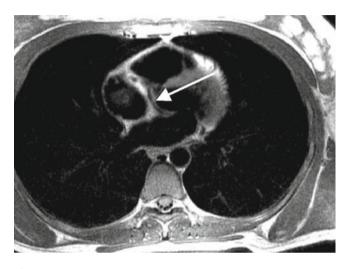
This 45-year-old patient presented with chest pain, underwent X-ray coronary angiography, and was found to have an anomalous left circumflex arising off the right coronary sinus. Regarding the question as to trajectory, the catheterization results were equivocal, prompting a cardiac MRI. This double-inversion recovery image was acquired in a breath-hold manner without administration of contrast, clearly demonstrating the benign nature of this anomaly. The vessel travels posterior to the aortic root (*arrow*) as the great majority, if not all, of anomalous left circumflex vessels do
